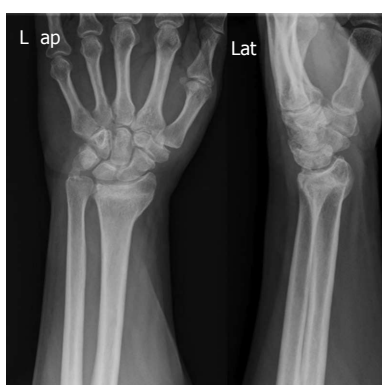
Preoperative X-rays showing an extra-articular dorsal malunion in a 51 years old man.
